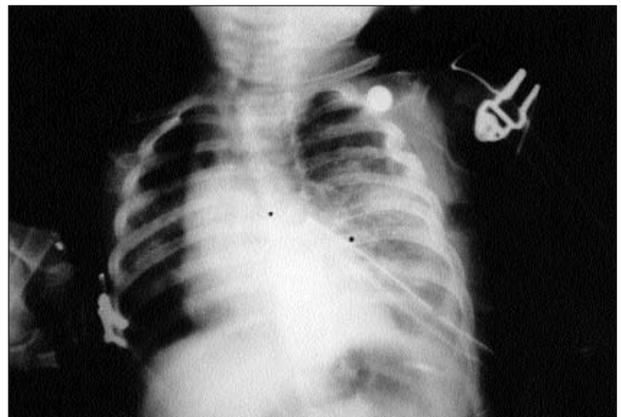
Chest x-ray showing left upper lobe emphysema with mediastinal shift in preoperative period.
